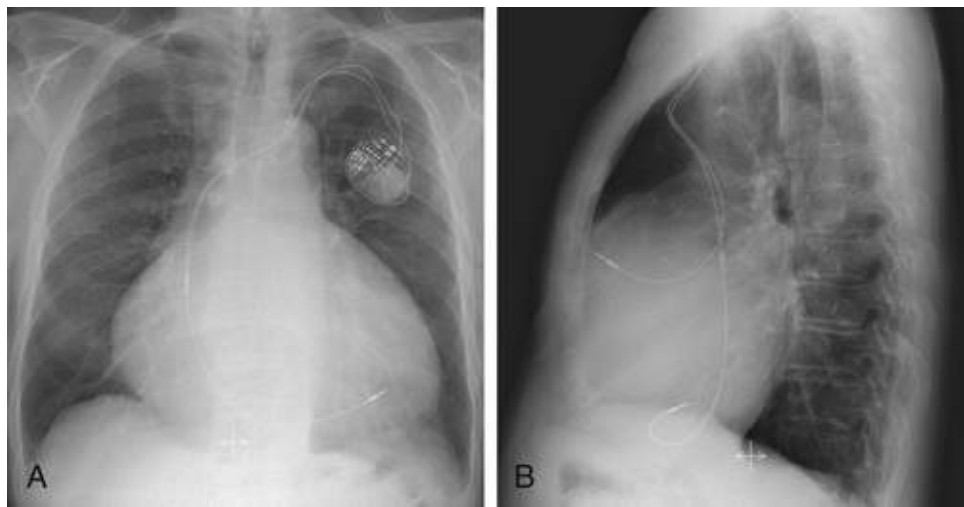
Right atrial and right ventricular enlargement in Ebstein anomaly. A, PA radiograph shows enlargement of the cardiac silhouette. The marked convexity of the right cardiac border is caused by the extremely dilated right atrium. The right ventricle is also much enlarged, as evidenced by the left lateral displacement of the right location of the tip of the ventricular lead of the cardiac pacemaker, which is located in the right ventricle. B, Lateral view reveals the long length of contact of the anterior cardiac border with the sternum, indicative of overall RV enlargement.
